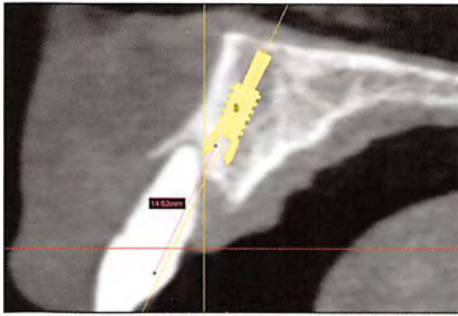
CBCT cross-sectional view showing how a CT scan can help orient the screw hole toward the lingual.
